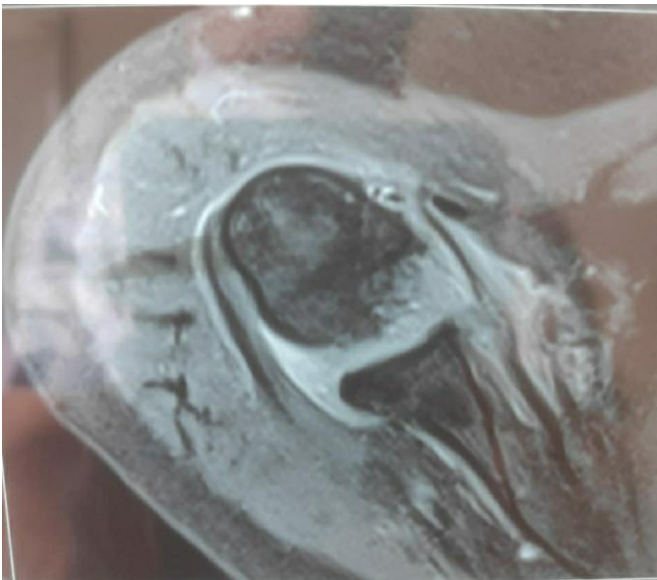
MRI of 68year/ female showing a Bankart's lesion
